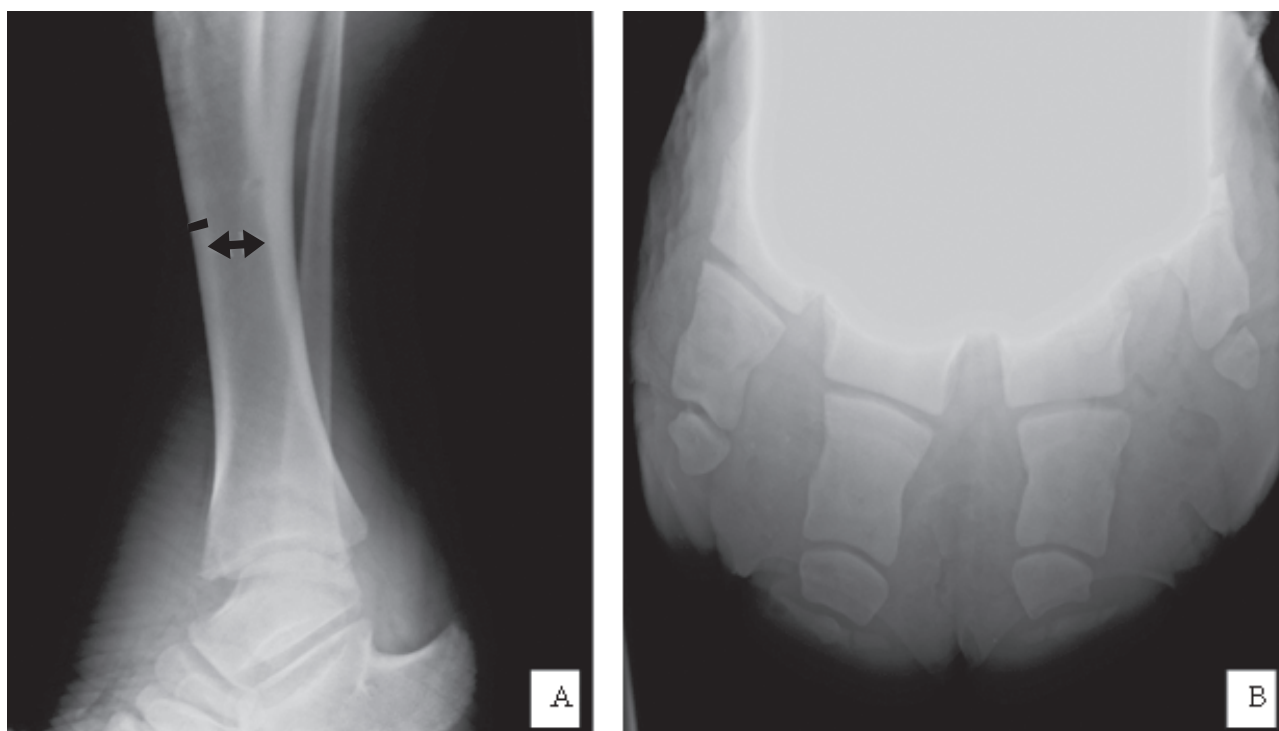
Radiographic images of tibia (A) and phalanges (B) of elephants. There was neither lesion nor abnormal bone alignment found from all radiographic images. In (A), the line indicates tibia cortex and two head arrow indicate diameter for the tibia.
